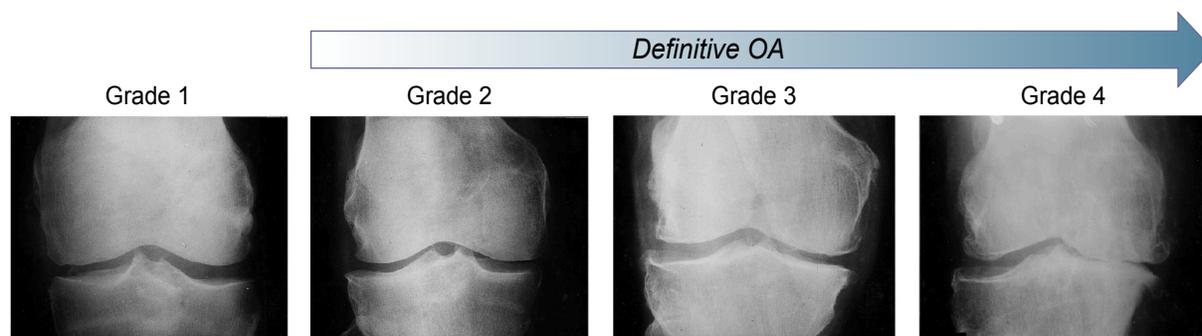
The Kellgren-Lawrence Atlas. Based on examples provided in an atlas (The Atlas of Standard Radiographs of Arthritis. *Rheumatology* 2005;44 Suppl 4:46-72), KLG includes the following four grades:
